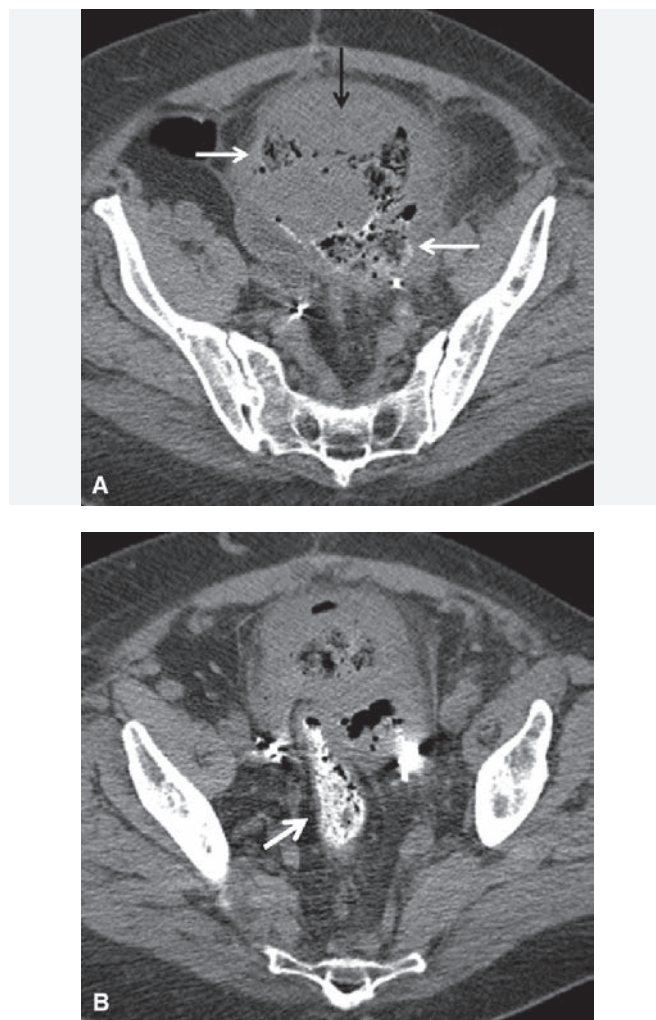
A 65-year-old woman with recurrent cervical cancer and fistula tract with the rectum. A: Axial CT image performed with enteric contrast shows the large recurrent mass in the midline pelvis (black arrow). There are mottled collections of gas and enteric contrast present within this mass (white arrows) suggesting fistulization with bowel. B: Slightly more inferior image demonstrates the contrast-filled rectum (arrow) partially encased by the mass. This was the site of fistulization.
